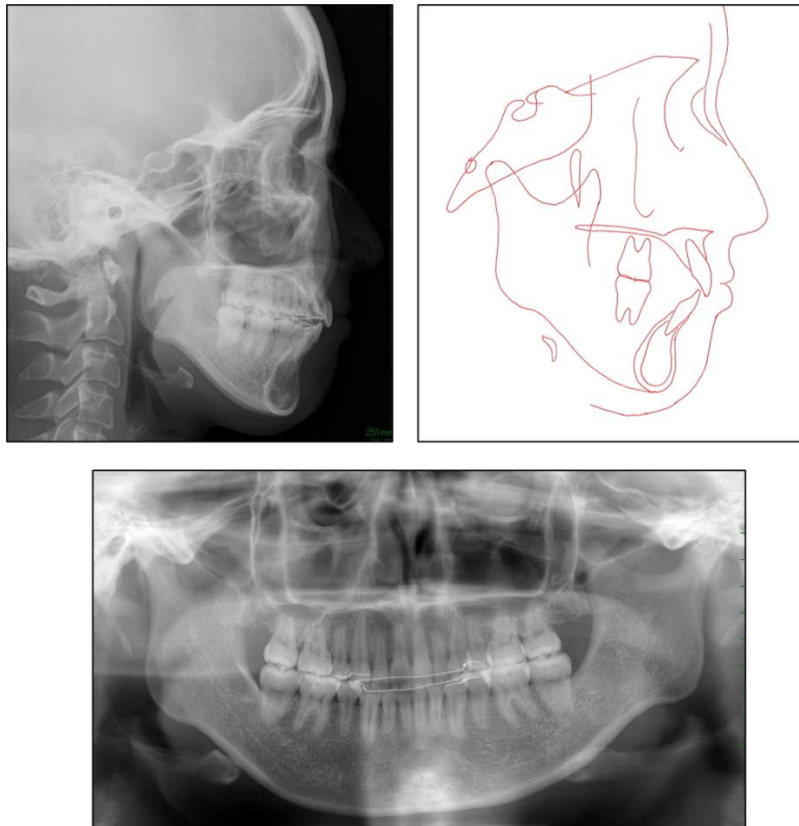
Posttreatment panoramic, lateral cephalometric radiograph and cephalometric tracing.
